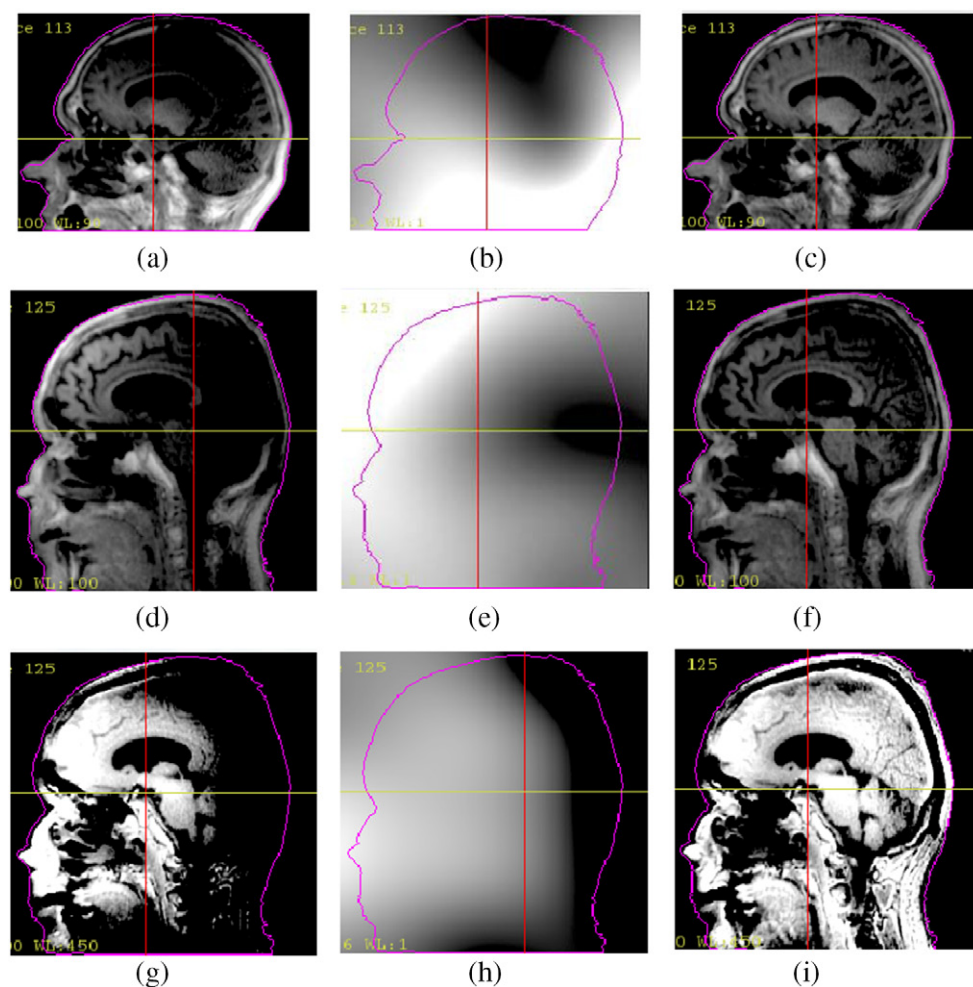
Uncorrected MR images (*a, d, g*), estimated bias fields using N4itk (*b, e, h*), and corrected MR images (*c, f, i*) of two patients. (*a*)–(*c*): UTE images acquired using pre-scan normalization on patient 1; (*d*)–(*f*): UTE images acquired using B1 normalization on patient 2; (*g*)–(*i*): PETRA images acquired using B1 normalization on patient 2. The images before and after using N4itk are windowed identically.
